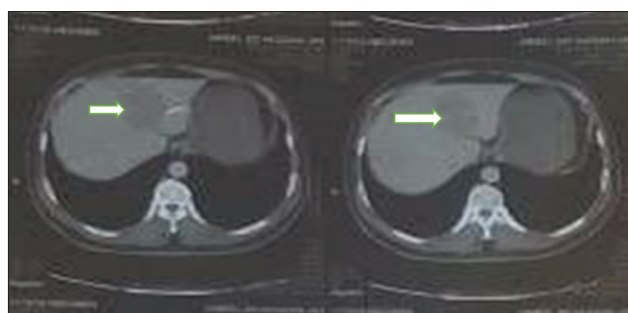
Triphasic computed tomography scan of the abdomen showing hypodense mass lesion in the liver (arrows).
